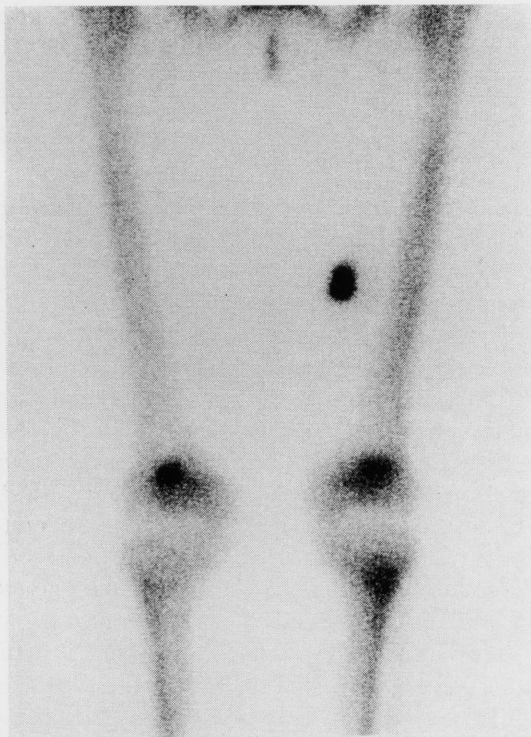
Anterior view of both thighs, supine. Tc-99m MDP two hour delayed image demonstrates intense uptake in the mass. The underlying femur has a normal scintigraphic appearance.
